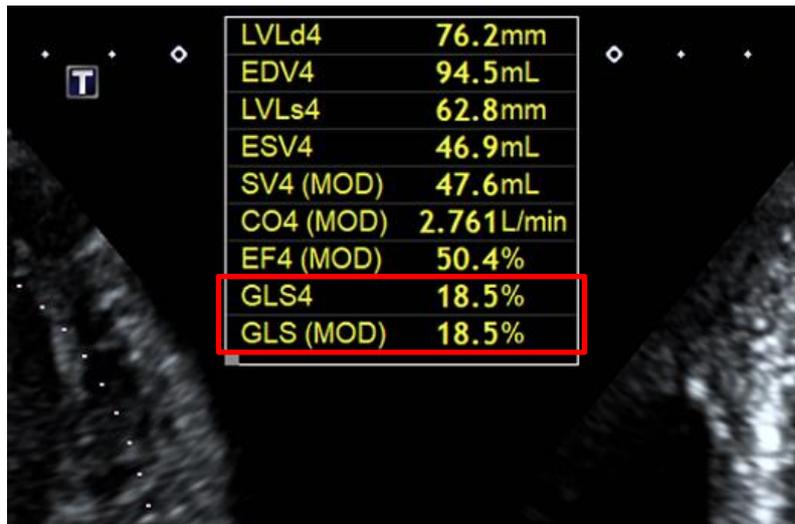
Global longitudinal strain (GLS) included in the Auto EF analysis in the apical 4 chamber view
